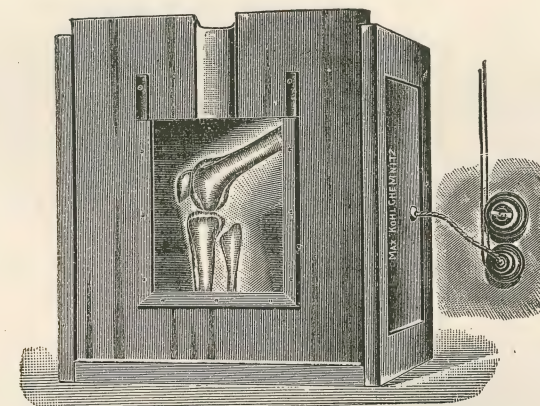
This figure very imperfectly shows a box for examining negatives with electric light inclosed behind the sliding front. The engraving is supposed to show a radiograph of the knee seen by transmitted light.
